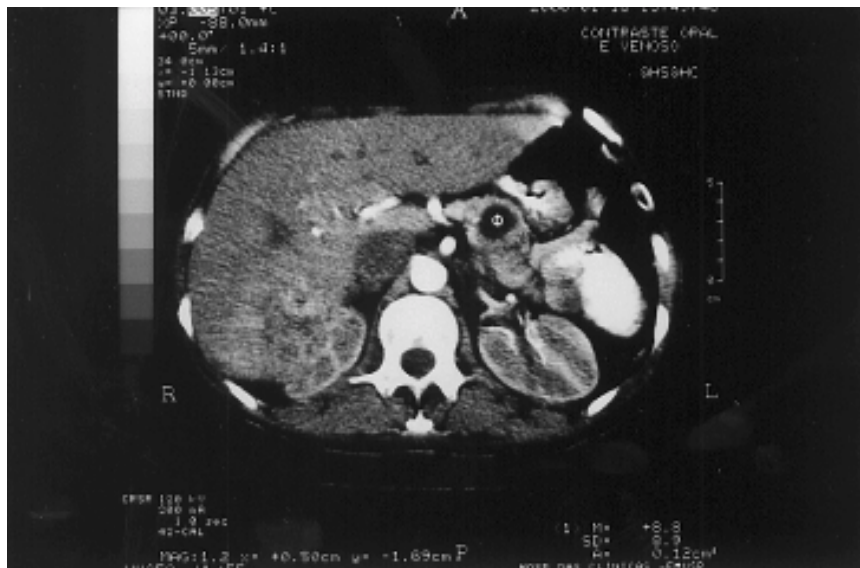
Pancreatic mass and metastatic nodules in the liver in computed tomography scan.
